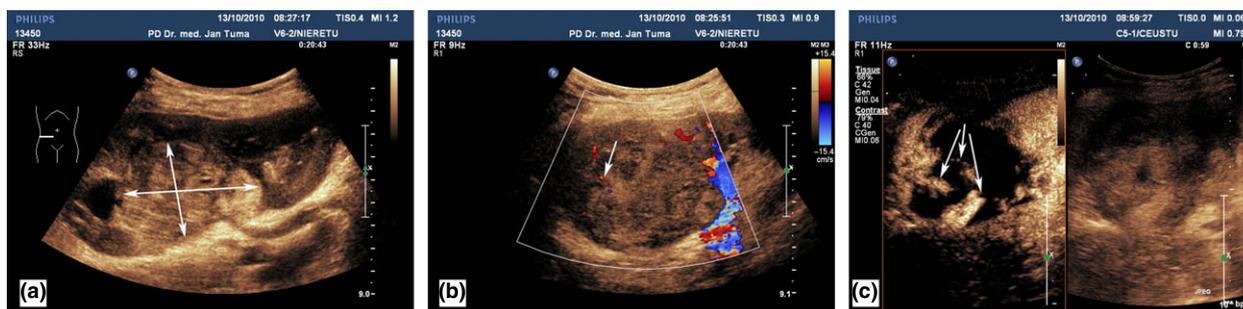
(a–c) Ultrasound images. (a) Hyperechoic inhomogeneous lesion 5.1 × 6.9 × 6.3 cm. (b) Color Doppler showing only minimal perfusion on the border of the lesion (arrow). (c) Contrast-enhanced ultrasound (CEUS) showing more perfused parts of the tumor (arrows).
